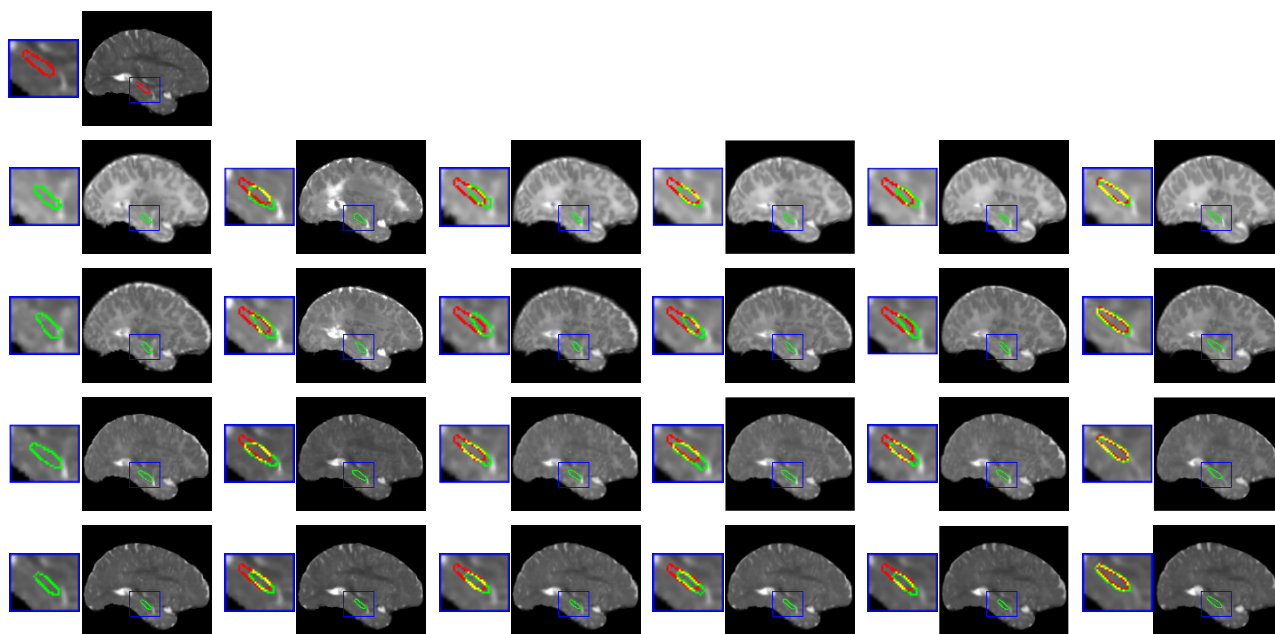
Visualization of the intrasubject registration of T2-weighted MR images. The arrangement of the sagittal slices is the same as in Fig. 5. Our proposed method still realizes the largest hippocampus overlaps (shown in the last column).
